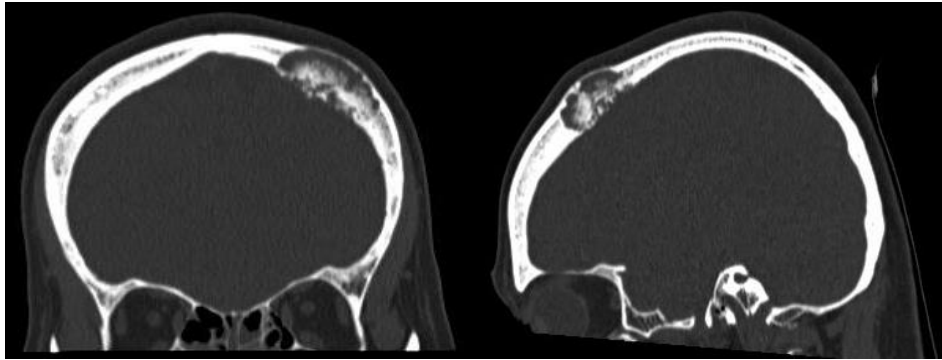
CT images showing hyperostotic and osteolytic areas involving the left frontal bone, without brain parenchymal involvement.
